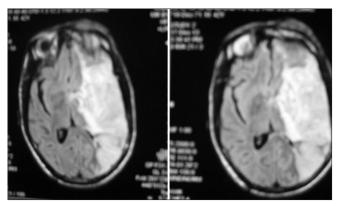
Magnetic resonance imaging brain showing large infarct in left fronto-tempero-parietal lobes, appears bright signal on diffusion weighted imaging sequences indicating restricted diffusion
